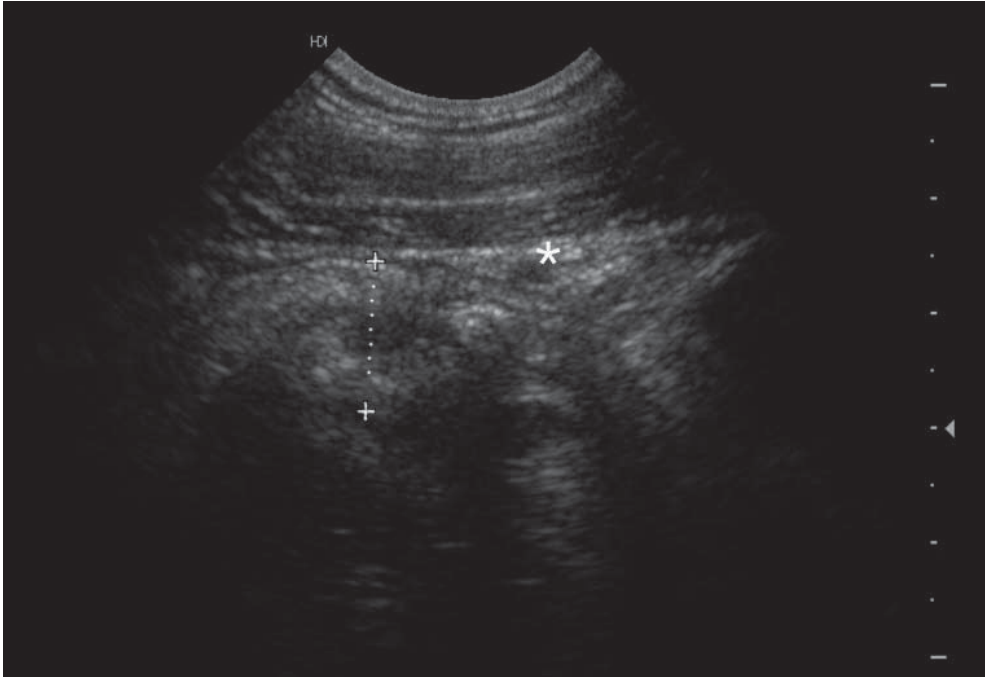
US of 28-year-old man shows echogenic incompressible inflamed fat (asterisk). The dotted line could be a possible enlarged retrocecal appendix, but an additional CT scan was needed to confirm the suspected diagnosis.
